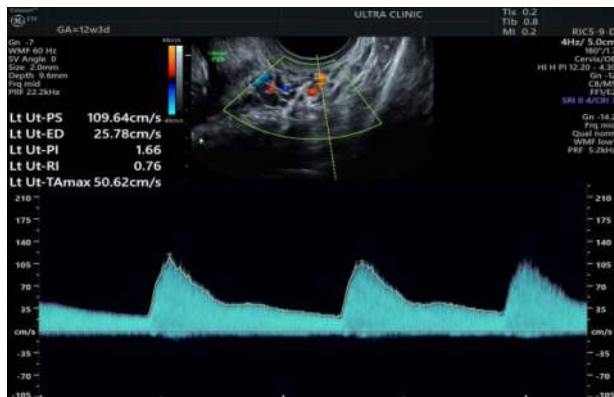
Uterine Artery Doppler
